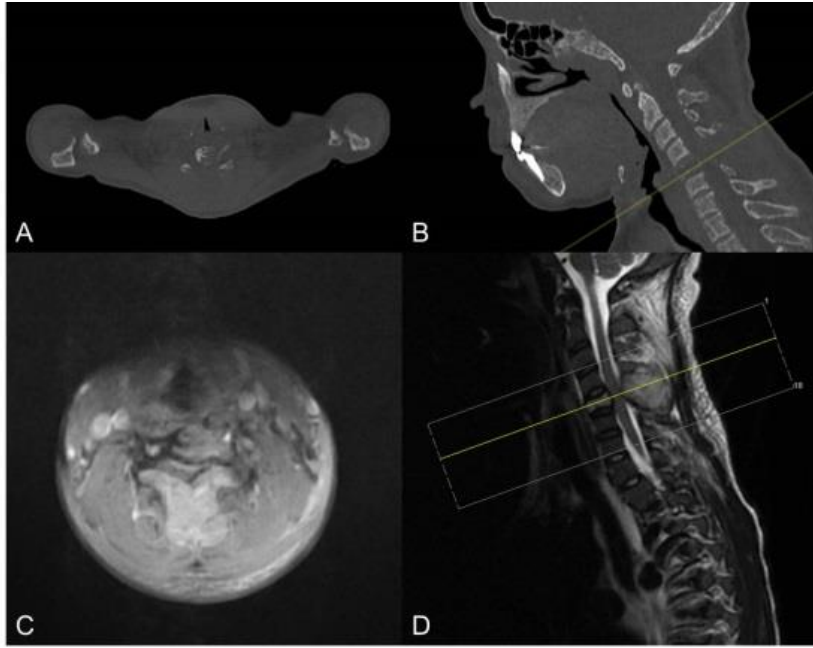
Pre-operative imaging. A, C5 axial and B, mid-sagittal slice of bone-windowed CT scan taken at presentation. C, C5 axial and D, mid-sagittal slice of T2-weighted MR scan taken at presentation.
